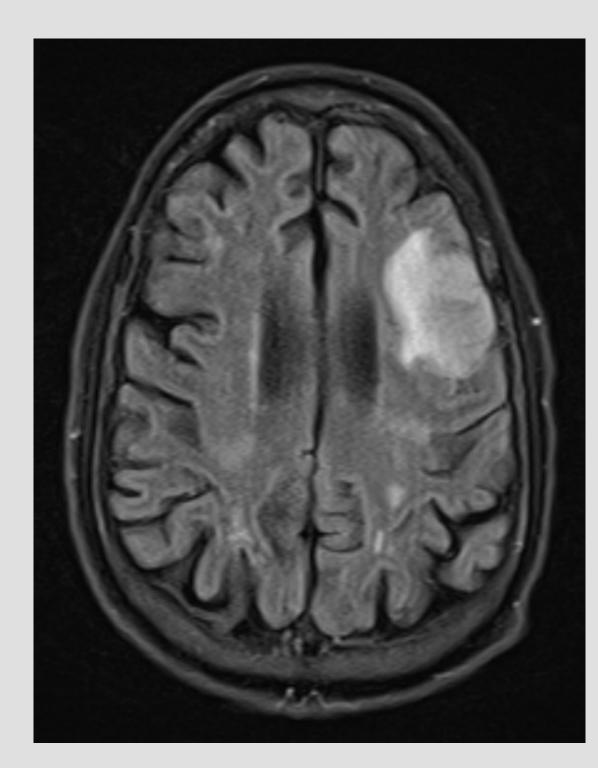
Fluid-attenuated inversion recovery (FLAIR) sequence showing multifocal foci of vasogenic edema
